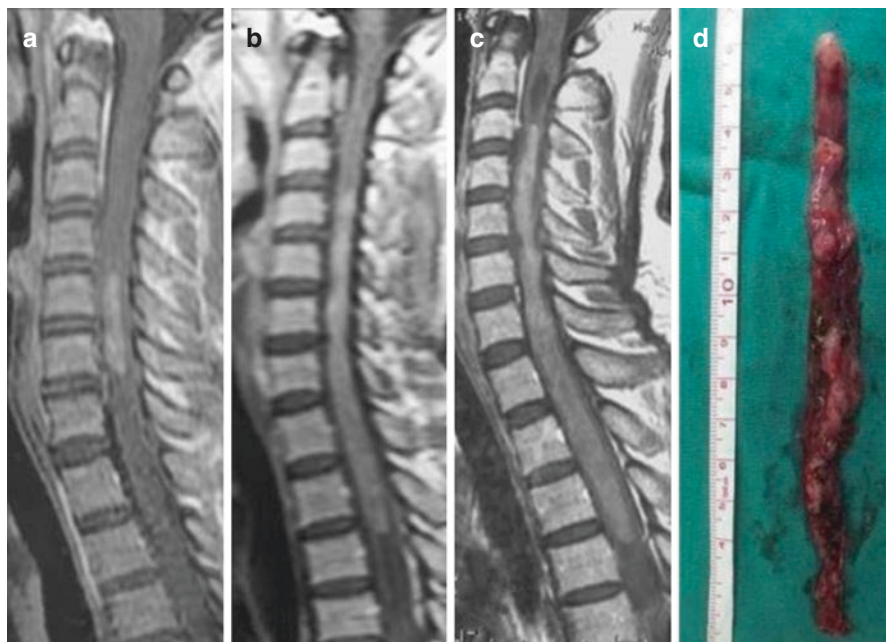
The progress of a multiple-segment cervical intramedullary ependymoma with NF2. The spine MRI were taken on the year of 2005 (a), 2008 (b), and 2009 (c). The lesion was removed en bloc in 2009 (d)
